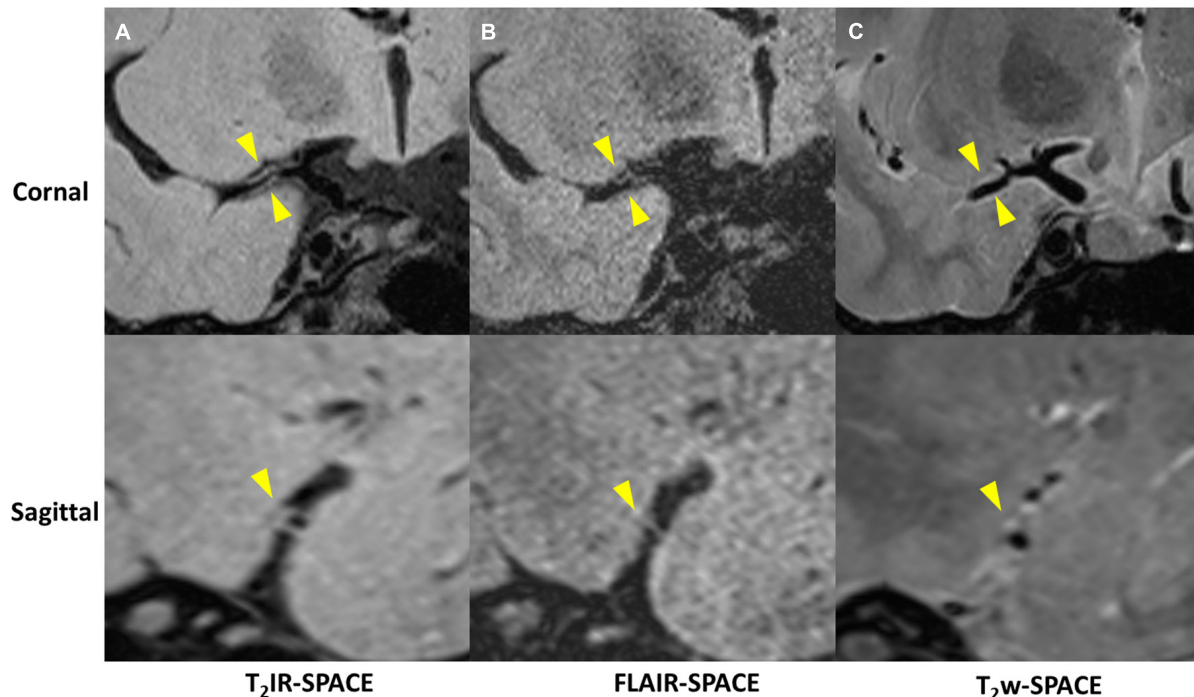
A 33-year-old female patient diagnosed with vasculitis. (A) T₂IR-SPACE, (B) FLAIR-SPACE, and (C) T₂w-SPACE images. Top: coronal view of the right MCA; Bottom: sagittal view of the thickened vessel wall pointed by the arrowheads. Among the three T₂w sequences, only T₂IR-SPACE depicted concentric wall thickening on the M1 segment of the right MCA; the vessel wall was not clear on FLAIR-SPACE, and most parts of the vessel wall were missing; the vessel wall on T₂-weighted SPACE imaging appeared normal.
